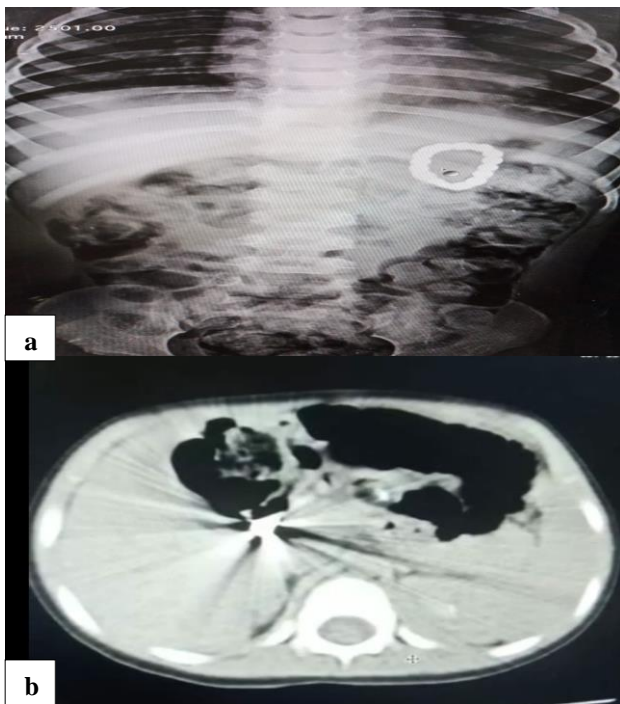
(a) X-ray showing a chain of 18 magnetic beads forming a ring left side of abdomen; and (b) CT scan showing multiple magnetic beads in shape of ring near the posterior wall of stomach suspected gastrocolic fistula.
